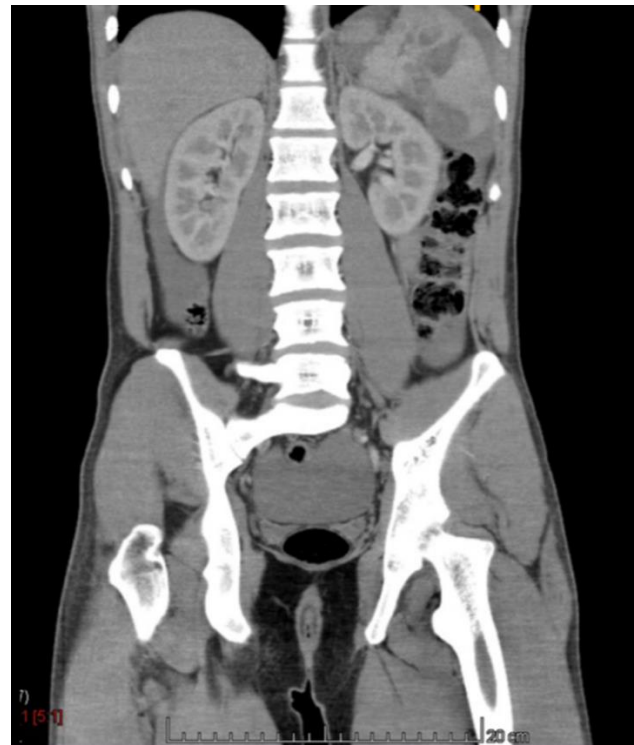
CT with hemoperitoneum.
